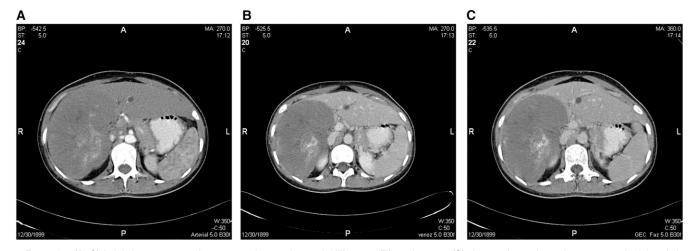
(A-C) Axial plane computed tomograpy images in arterial (A), portal (B), and venous (C) phases show a hypodense mass which is subtle on arterial phase (A) and better depicted in portal (B) and venous (C) phase images because of contrast enhancement of normal liver parenchyma. The lesion itself does not enhance in the later phases and is better appreciated because of increased contrast between lesion and liver parenchyma. Also, low density calcification is noted within the lesion which is typical of *Echinococcosis*.
